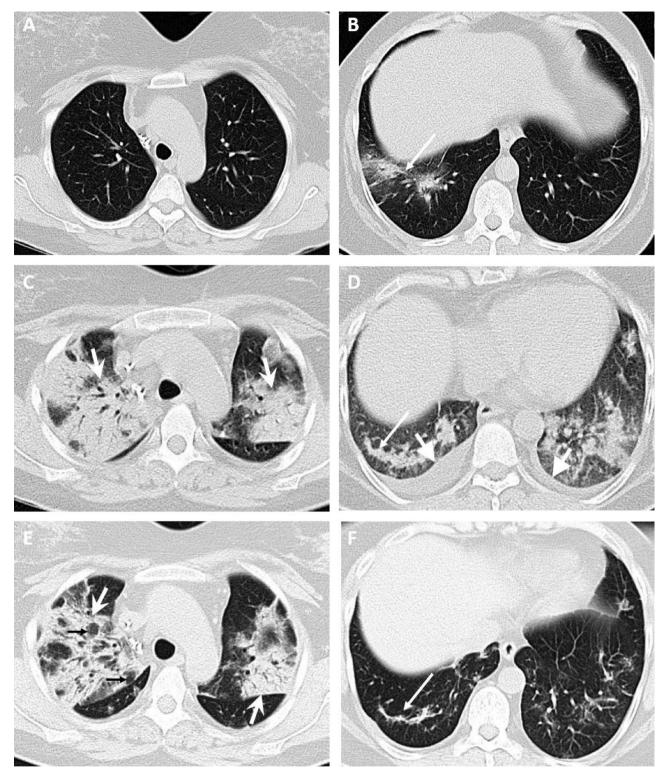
A 49-yr-old woman presented with a dry cough, sore throat, headache, and a history of kidney transplantation 17 yr previously. (A,B) Computed tomography (CT) images obtained 3 d after the onset of symptoms show patchy ground-glass opacity in the right inferior lobe with slight central consolidation (long arrows). (C,D) CT images obtained 25 d after the onset of symptoms with secondary superimposed bacterial pneumonia show diffuse bilateral ground-glass opacity and consolidation with air bronchogram (wide arrows) predominantly in the upper lobes and bilateral mild plural effusion (thick-headed arrows). (E,F) CT images obtained 28 d after the onset of symptoms and intravenous antibiotic therapy show evolution of the area of consolidation with vacuolar signs (small black arrows) in the right upper lobe and fibrotic bands (long arrow) in the right lower lobe. The patient was discharged after 37 d.
